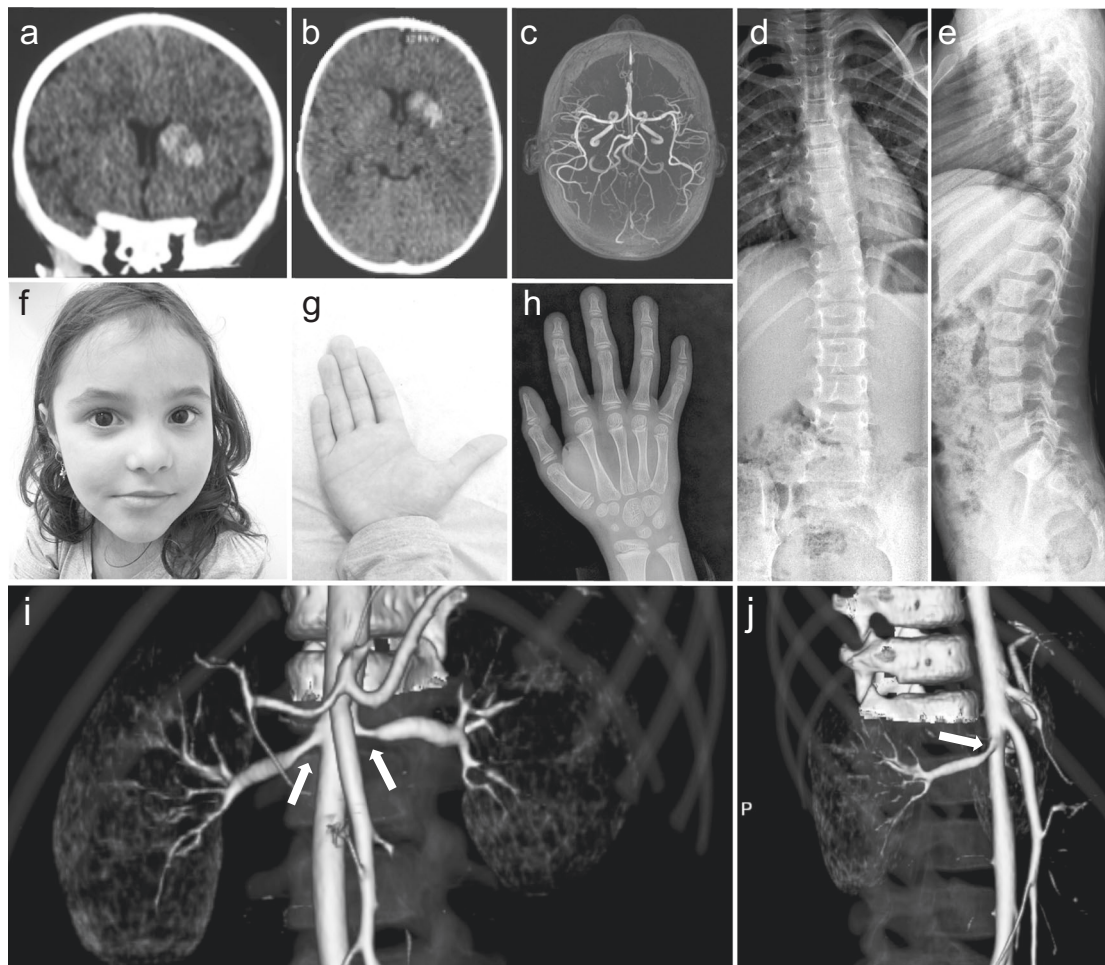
Clinical features of the patient. a, b Axial and coronal views of head CT taken just after stroke at 1 year old, respectively. A high-density area indicated left thalamic caudate hemorrhage without midline displacement with normal ventricles. c Magnetic resonance angiography showed no abnormal findings. d, e Spinal bone X-rays, with frontal and lateral views, which show mild scoliosis. f Photograph
